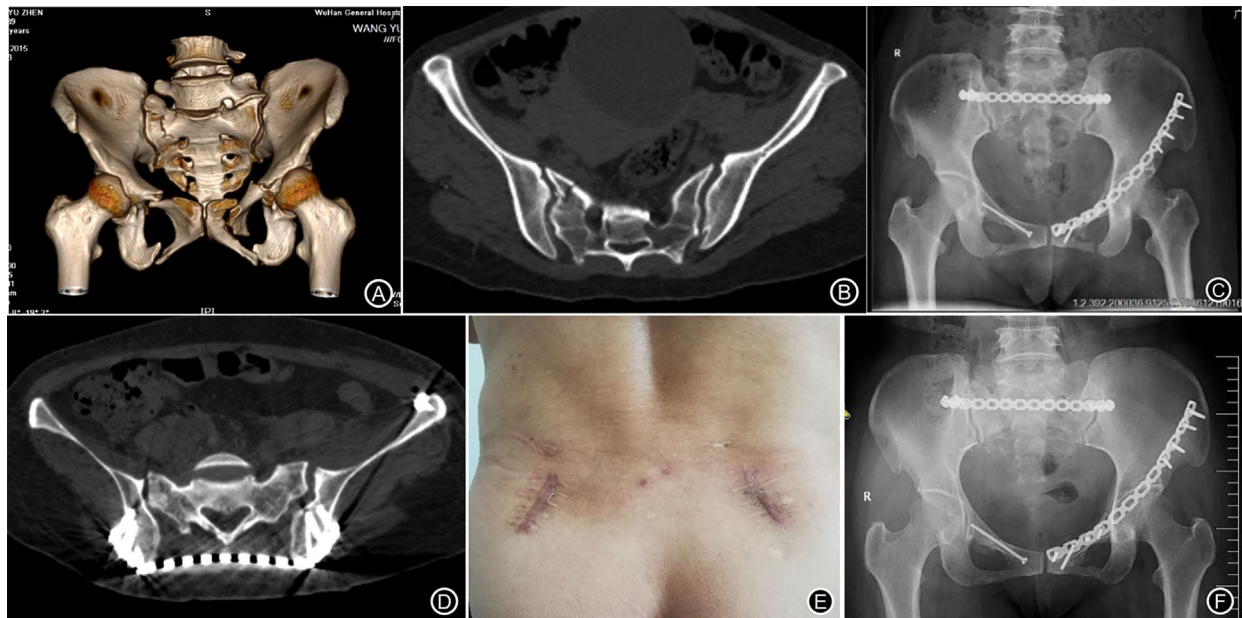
(A-B) Female, 46 years old, was injured by fall from a height. The patient accepted operation 6 days after injury. Preoperative three-dimensional and axial plane view of CT showed the right Zone II unstable sacral fracture. (C) Postoperative X-ray of AP showed closed reduction and minimally invasive percutaneous plate was applied to treat Zone II unstable sacral fractures, the pubic rami fracture was treated with intramedullary fixation and reconstruction plate. (D) Axial plane view of CT showed the shape of the plate and the IS screw position is excellent. (E) Incision photos showed incision scar healing. (F) Radiographs of 6 months postoperatively showed the sacral fracture complete union
